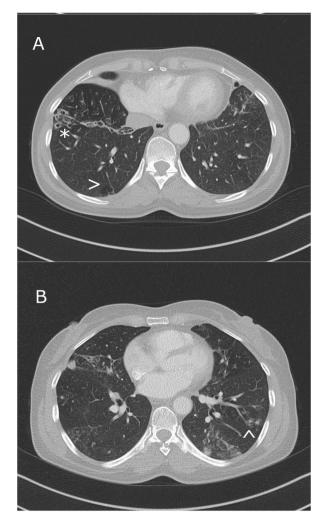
Transverse CT-scans of the index patient. Scans showing areas of bronchiectasis (*), emphysema (>) in image A and bronchiolitis with tree and bud opacity (^) in image B.
